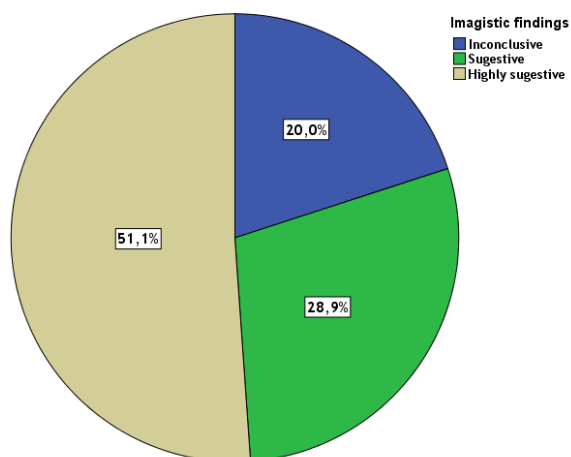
Accuracy of CT examination
